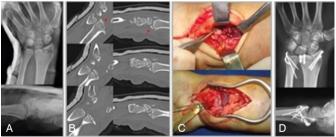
A) Dumontier's Type II, B) CT scans showing dorsal dislocations and large interposed volar fragment, C) volar rim of the radio rotated 1800 and it's temporary fixation after reduction, D) Final radiographs.
